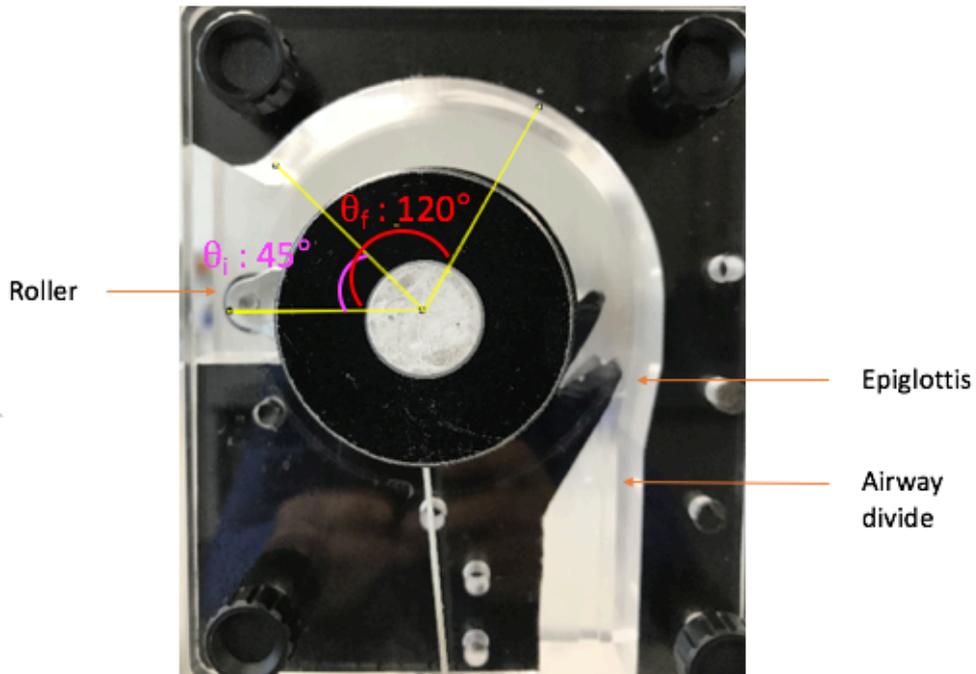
CT throat model with measured angles.
